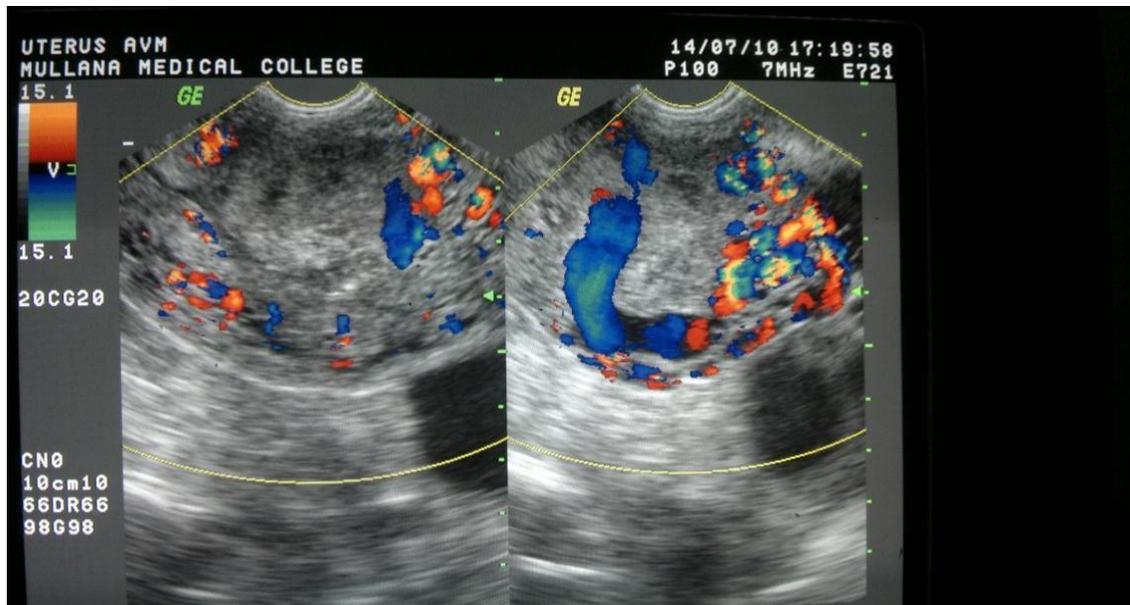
US Color Doppler view showing retained products of conception with AV Malformations.
